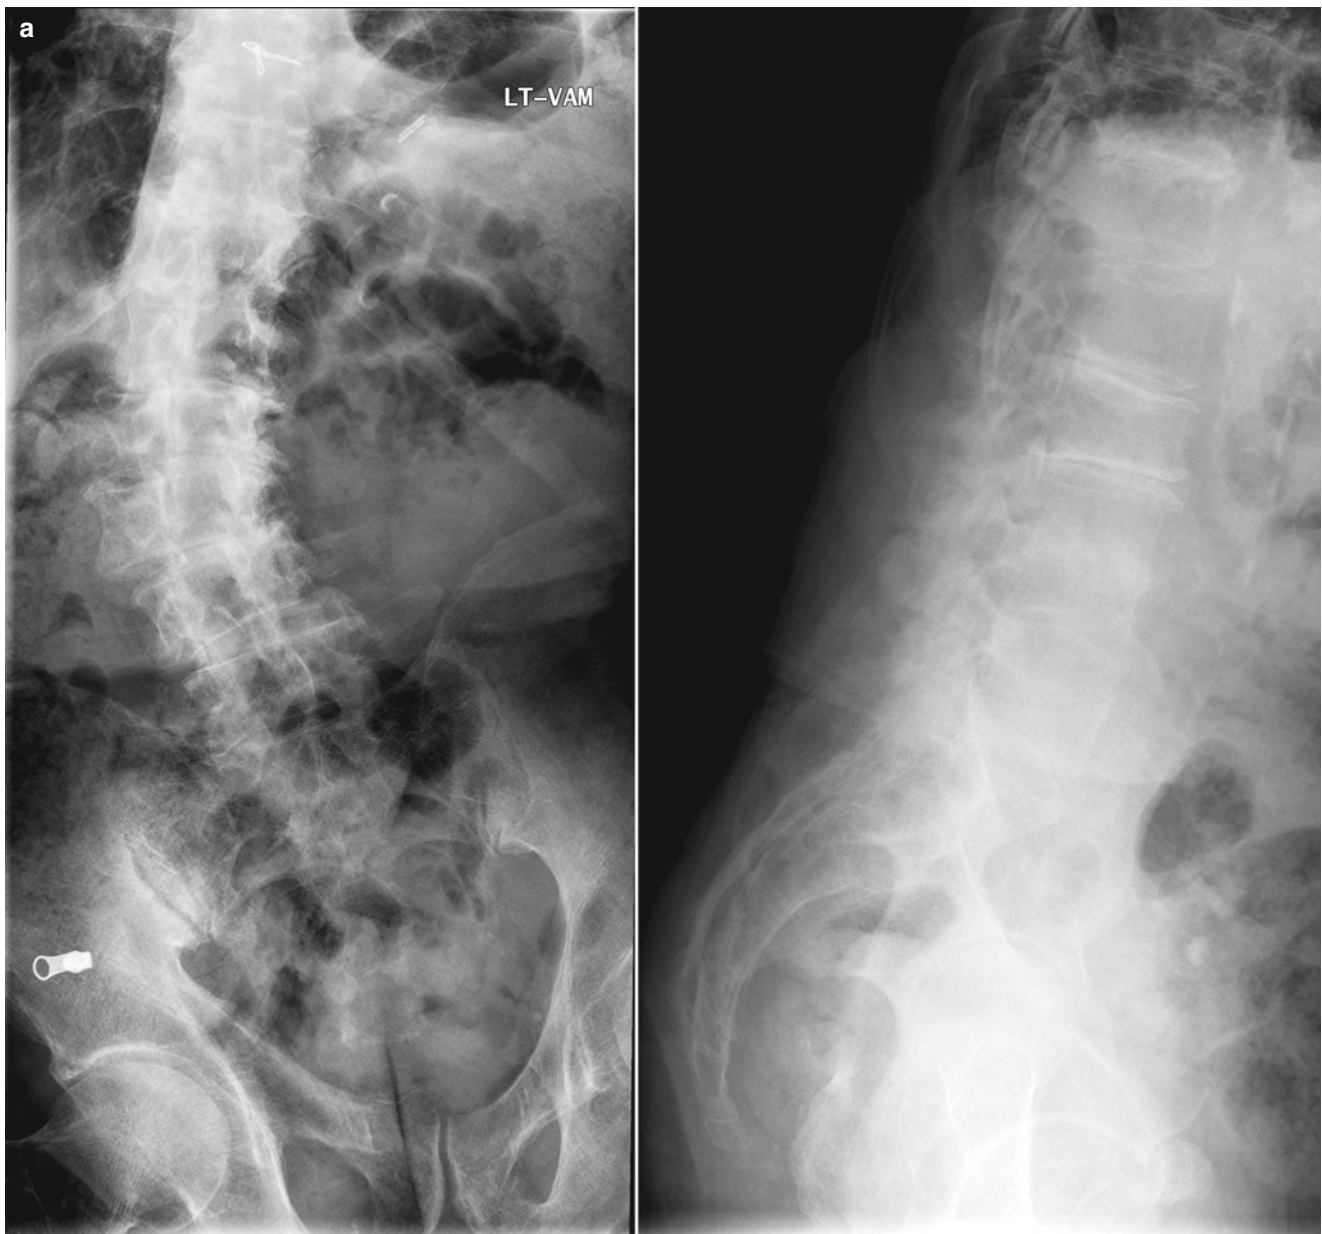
AP and lateral radiographs (a) and selected T2-weighted magnetic resonance image (b) demonstrating the typical features of adult scoliosis including a predominantly lumbar curve, lumbar kyphosis, significant disc and facet joint degeneration, and spinal stenosis
